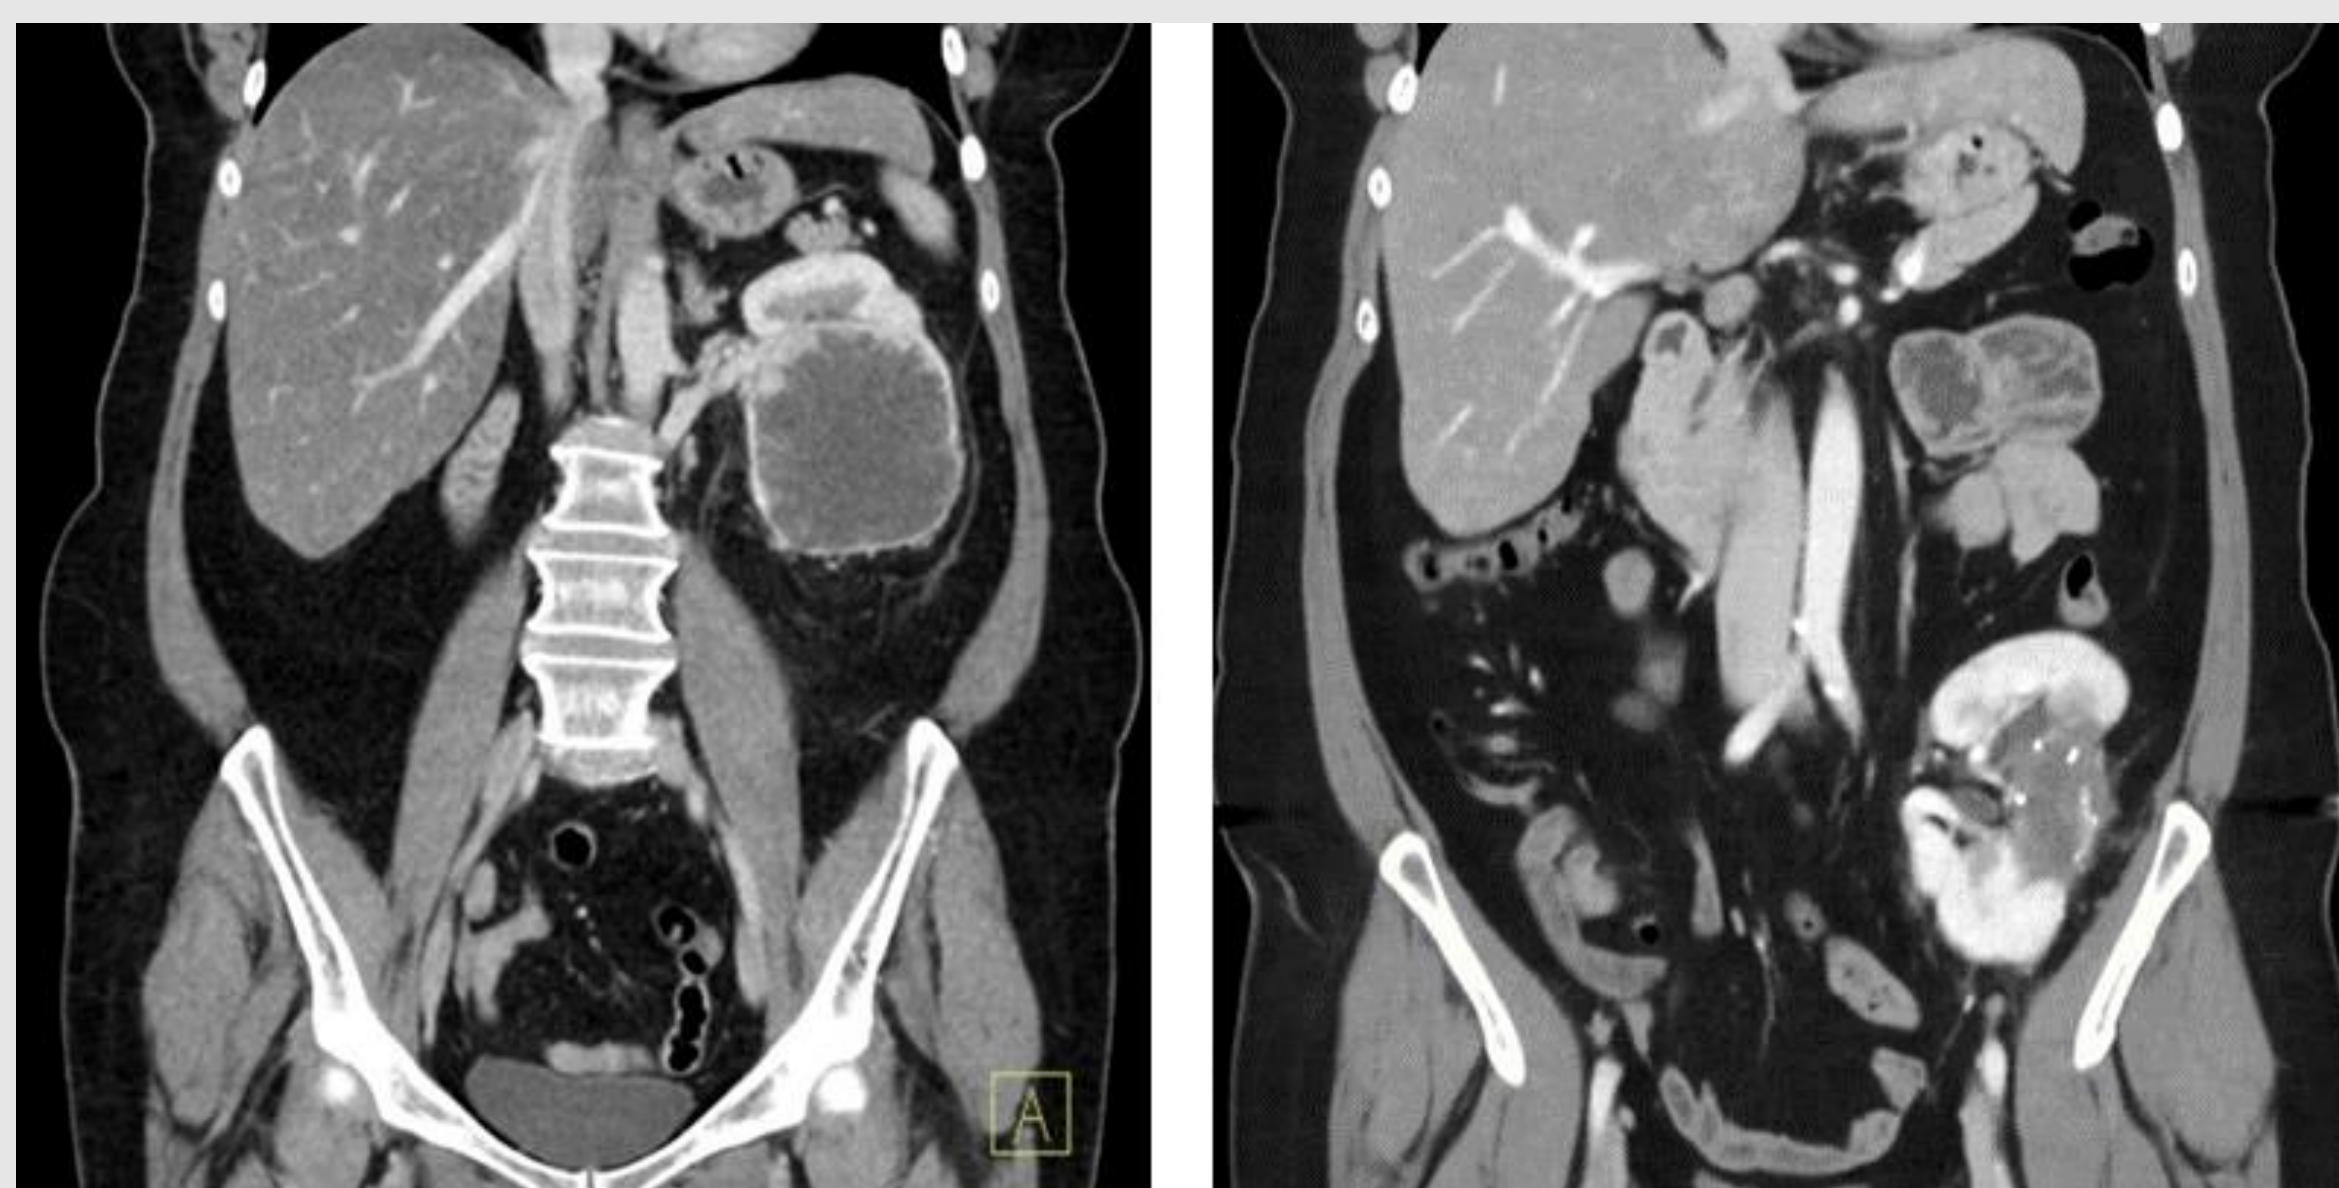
Pre- and post-operative CT, venous phase
